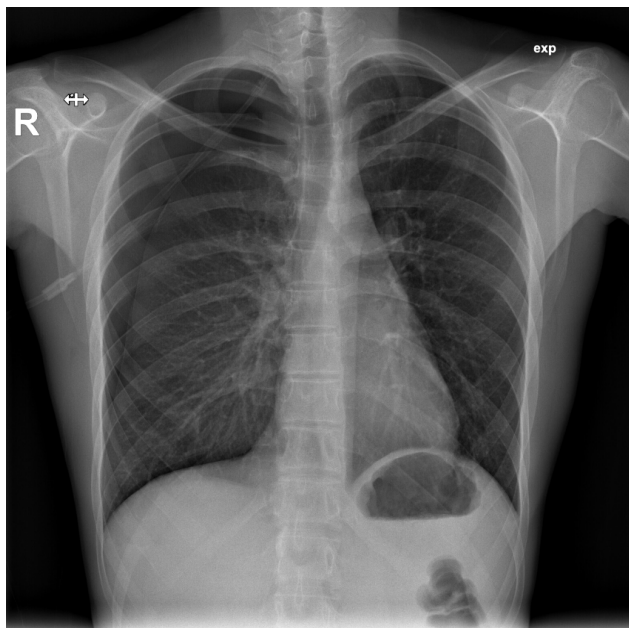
Posteroanterior chest radiograph on admission showing a moderate right-sided pneumothorax.
